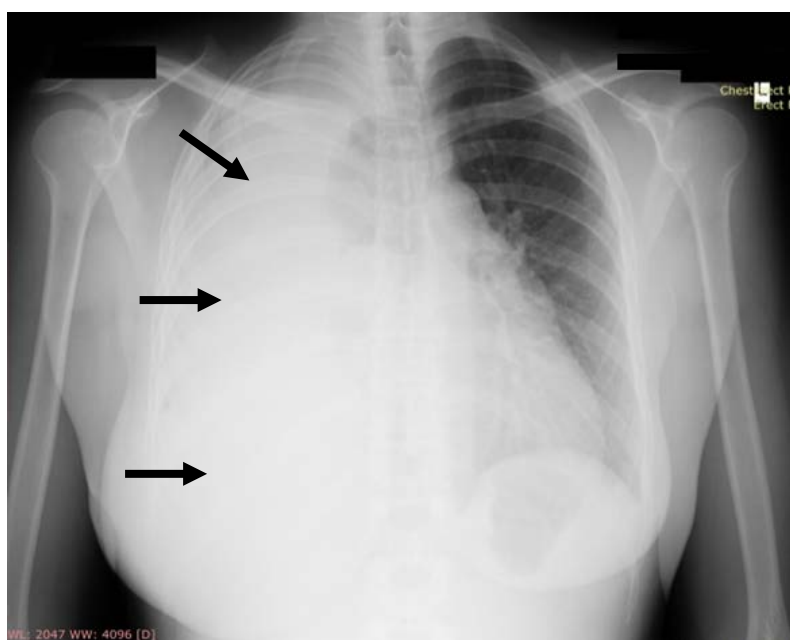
Chest X-ray showing uniform opacity of the right hemithorax (arrows).
